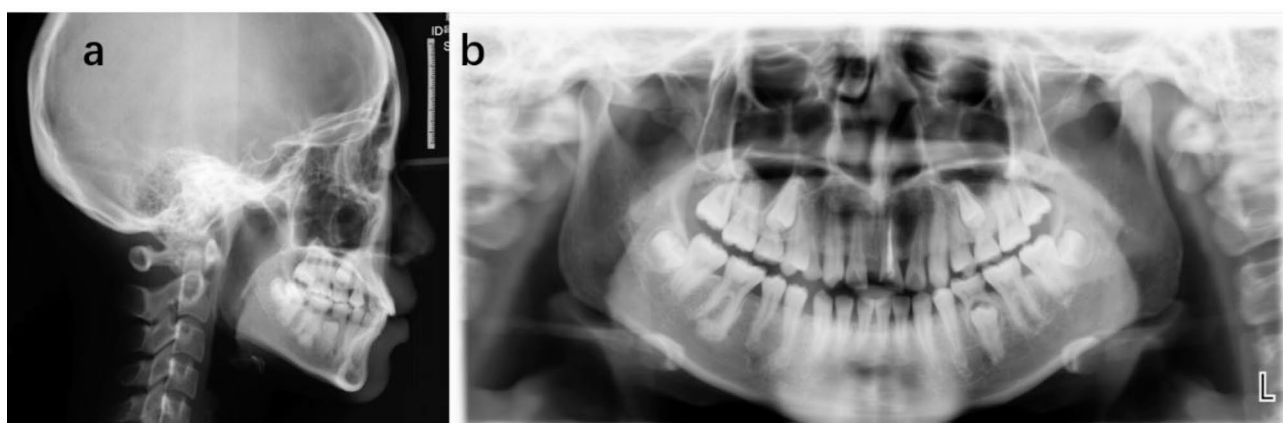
Pre-second phase of orthodontic treatment records: a lateral cephalogram. b panoramic radiograph
